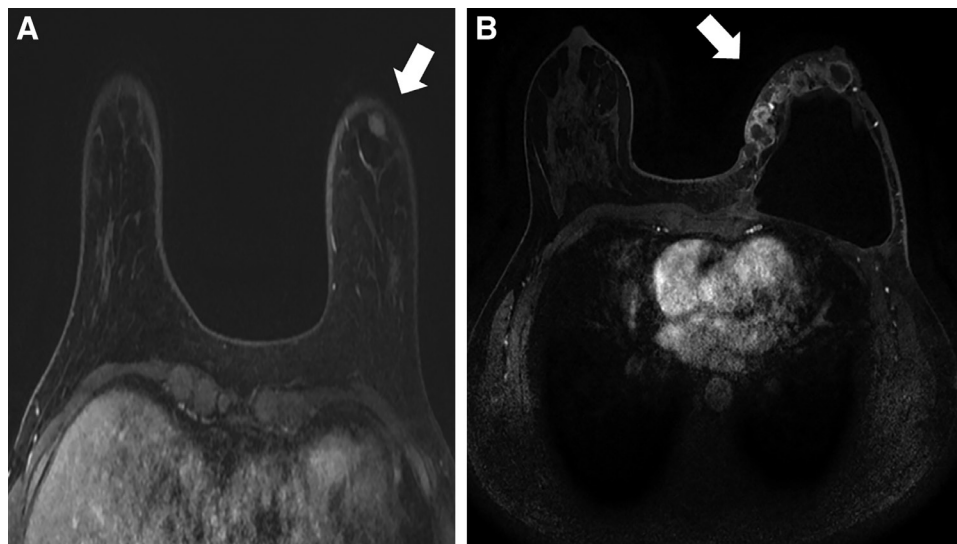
Breast magnetic resonance image (MRI). A, Preoperative MRI showing a foci adjacent to the skin but not involving it. B, Local subcutaneous early recurrence after an implant-based reconstruction.
